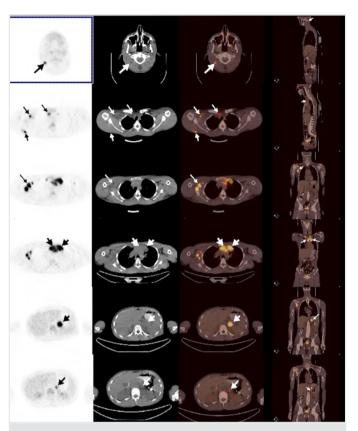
A 16-year-old patient with nodular sclerosing type HD with favorable prognostic factors on pretreatment evaluation. Following 4 cycles of ABVD regime, the post-treatment PET/CT study demonstrated residive disease in multiple supradiaphragmatic and infradiaphragmatic lymphatic regions as well as in the left adrenal gland and in soft tissue of the left arm as shown on the selected slices above. Despite of further agressive chemotherapy applications, a remission status could not be managed and the patient died after 31 months
